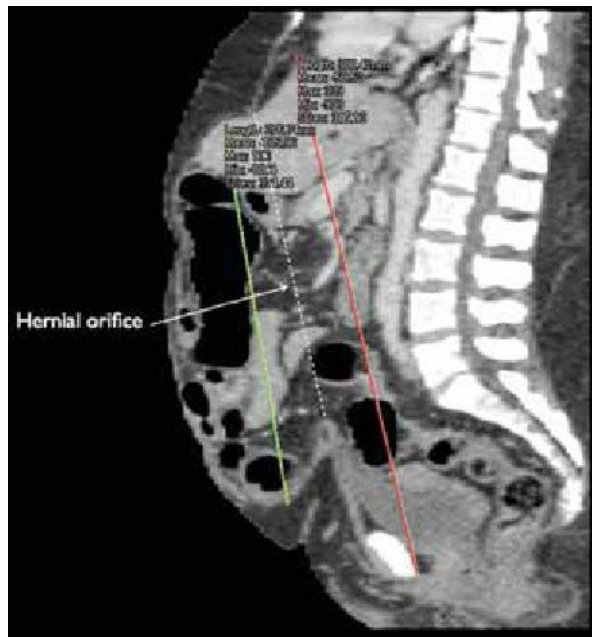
CT with sagittal reconstruction used to calculate the ratio of the hernia to abdominal cavity volume. Dotted white line represents hernia aperture. Red line indicates length of abdominal cavity, and green line the length of the hernia sac.
